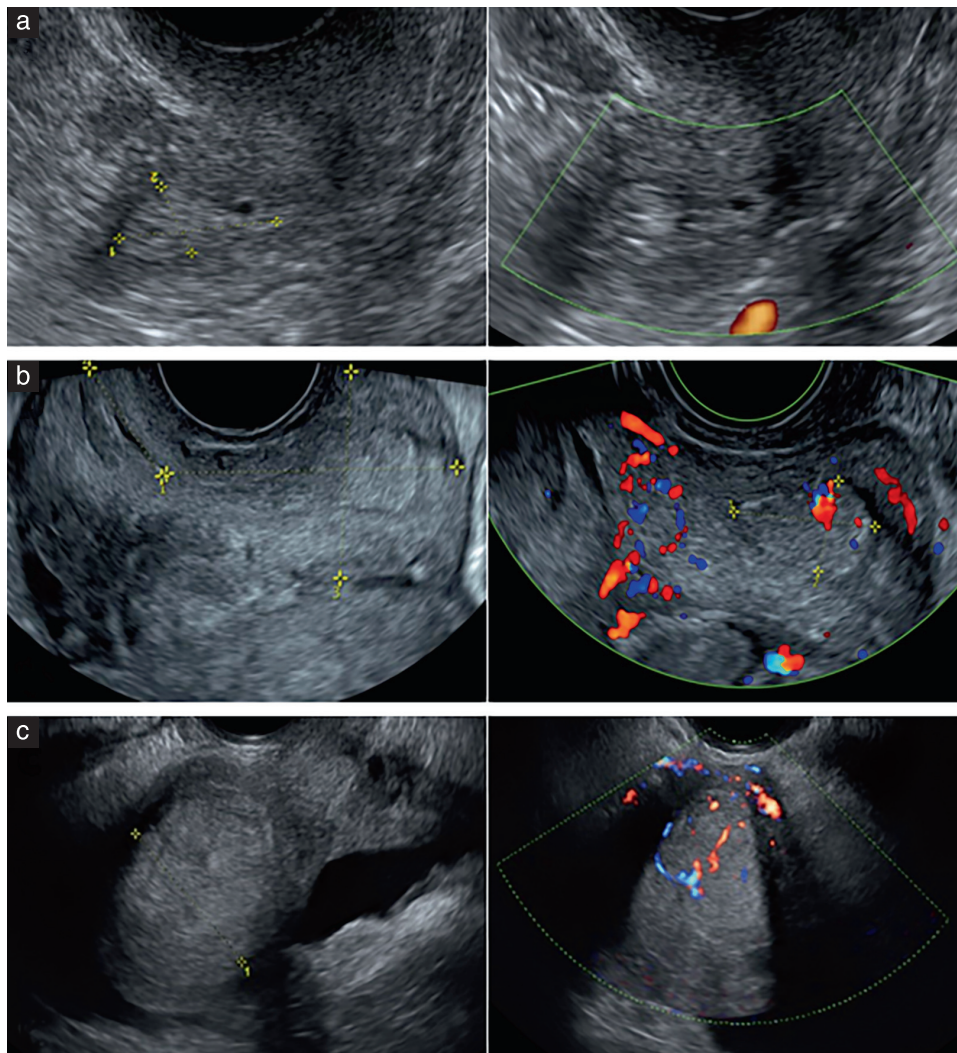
(a) Grayscale and corresponding power Doppler images of a Grade-1 endometrioid cancer, Stage IA, at a pulse repetition frequency (PRF) of 0.6 kHz. (b) Grayscale and corresponding color Doppler images showing a single dominant vessel and bright edge sign in a Grade-1 endometrioid cancer, Stage IA, possibly reflecting cancer in a polyp, at a PRF of 0.9 kHz. (c) Grayscale and corresponding bidirectional power Doppler images at a PRF of 0.3 kHz, in a patient with a serous endometrial cancer, Stage IVB, presenting with ascites, diffuse peritoneal carcinomatosis, omental and infiltrative mesenteric deposits and bilateral pleural effusion.
